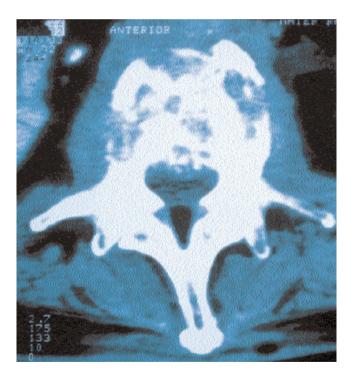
A CT scan of a spinal metastatic tumour showing vertebral body destruction.
